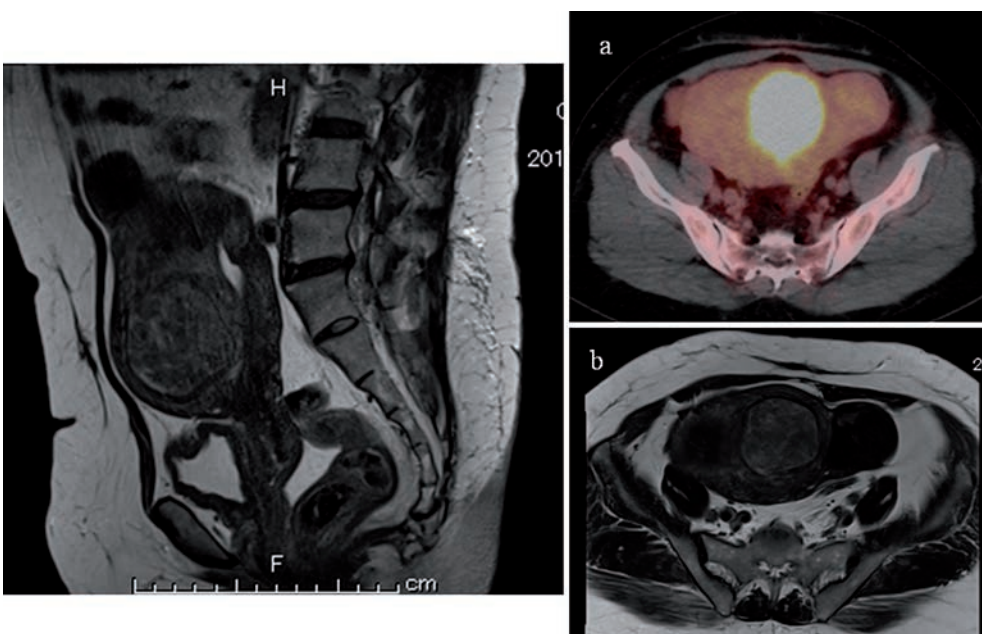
T2-weighted MRI revealing an enlarged uterus and multiple round nodules. Comparison of a nodule by PET-CT (a) with MRI (b).
